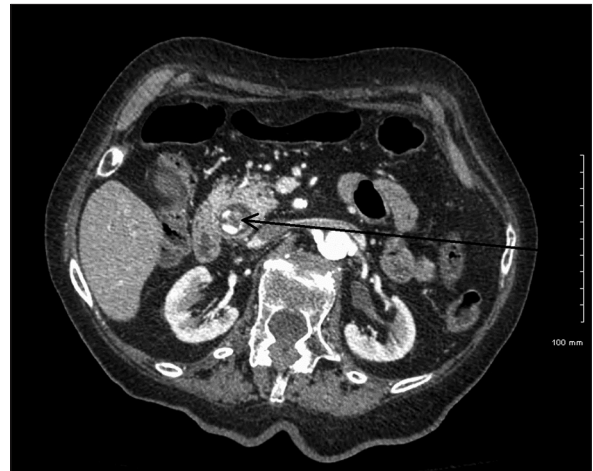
Transverse section from a Computed tomography scan of the abdomen showing a stone in the common bile duct. Arrow pointing to the stone
